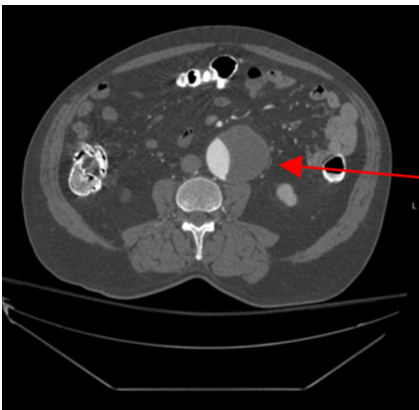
A computed tomography scan (axial) showed an abdominal aortic aneurysm with no evidence of rupture.
